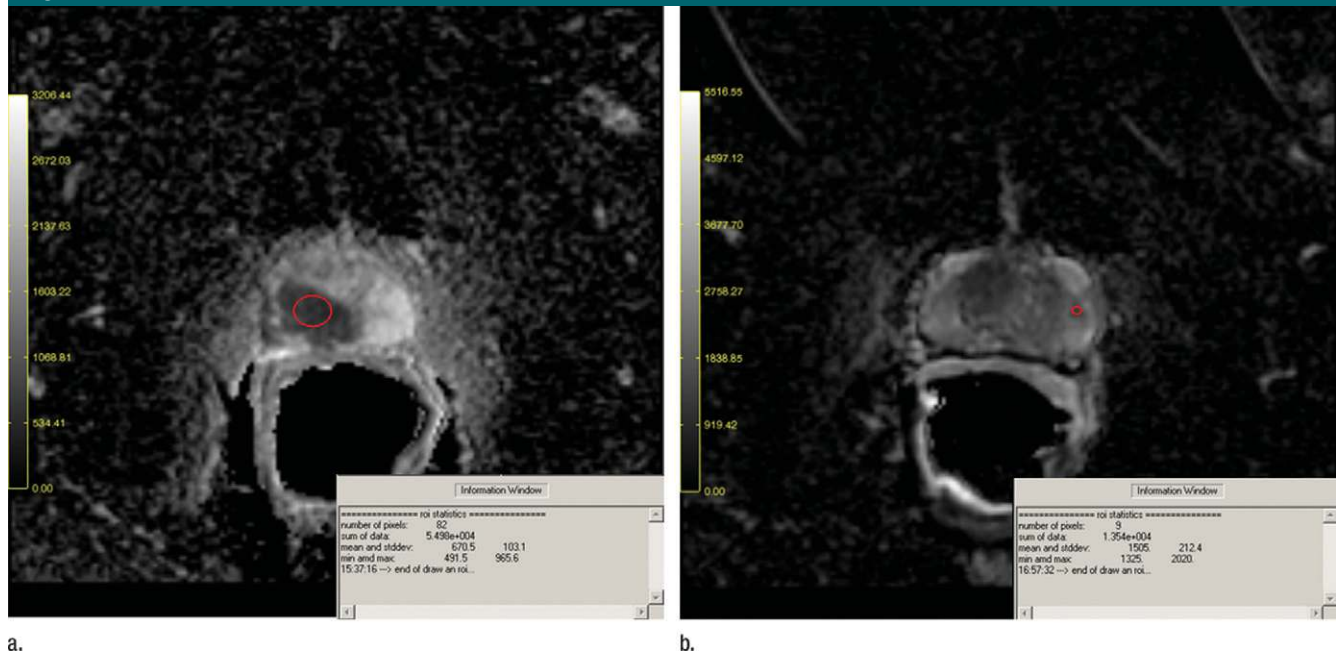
Screen captures of the DW MR imaging tool used for analysis. (a) Region of interest (red) in a tumor in the right peripheral zone (PZ) with a Gleason score of 4+4 has a mean ADC of $(670.5 \pm 103.1) \times 10^{-6}$ mm²/sec, whereas (b) that in a tumor in the anterior left of the prostate with a Gleason score of 3+3 has a mean ADC of $(1505 \pm 212.4) \times 10^{-6}$ mm²/sec.
